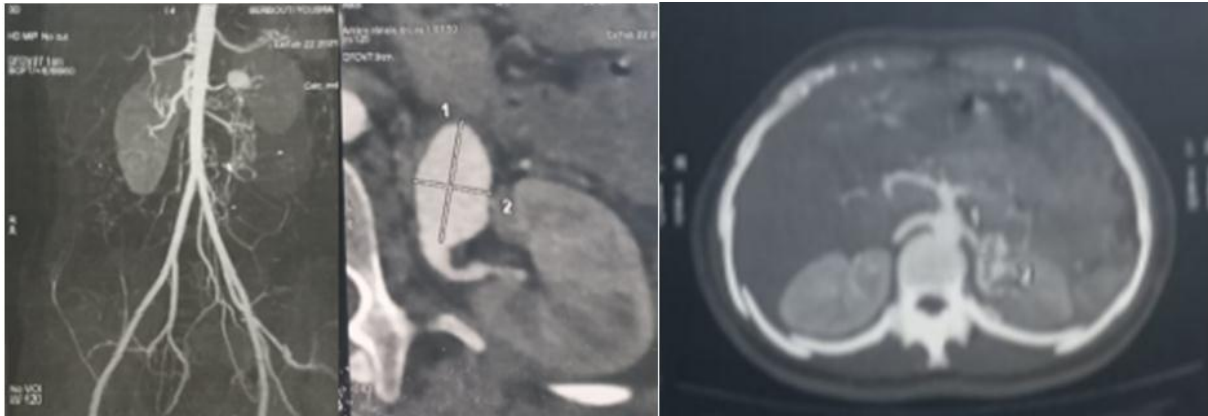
CT angiography of the renal arteries objectifying an aneurysm of the left renal artery.
